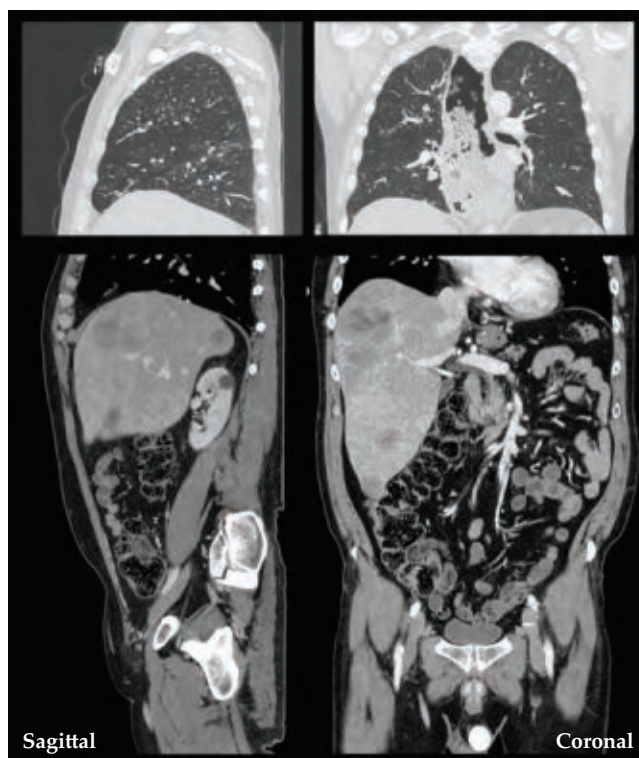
SAGITTAL AND CORONAL perspectives of the torso. Images of the thorax (top) and abdomen and pelvis (bottom) demonstrate the remarkable clarity with which computed tomography (CT) imaging can depict human anatomy. Excellent contrast between air, tissue, and bone makes CT scans of the lung essential for diagnosing many pulmonary disorders. A vascular contrast agent containing high-atomic-number iodine can be injected to enhance the contrast of soft tissues in the abdomen and pelvis and make blood vessels and cardiac chambers visible. (Courtesy of Canon Medical Systems, USA.)
